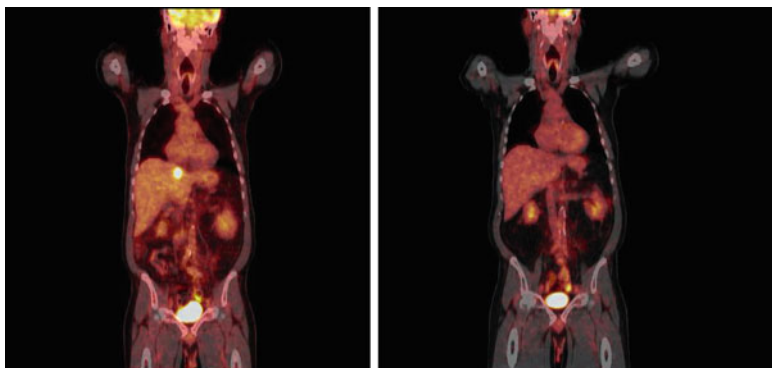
18F-FDG-PET/CT images demonstrating a hypermetabolic left lobe metastasis (*left*). The *right* scan was performed after 1 month of treatment of imatinib therapy showing complete resolution
